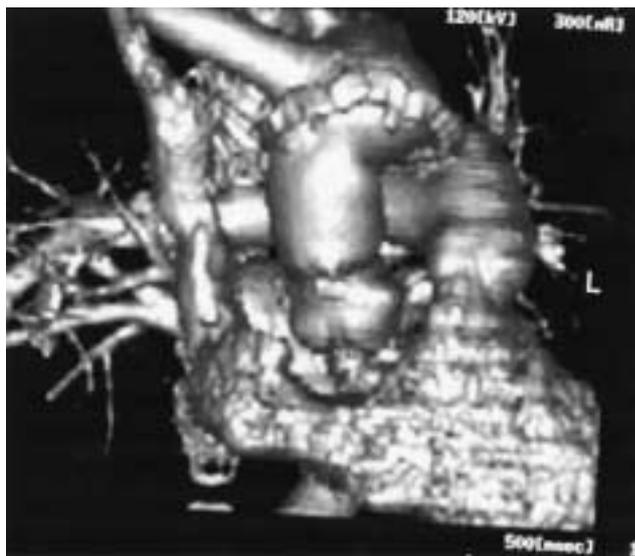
Three-dimensional reconstruction of computed tomographic scan (3D-CT). 3D-CT confirmed excellent results of the anastomotic sites.
